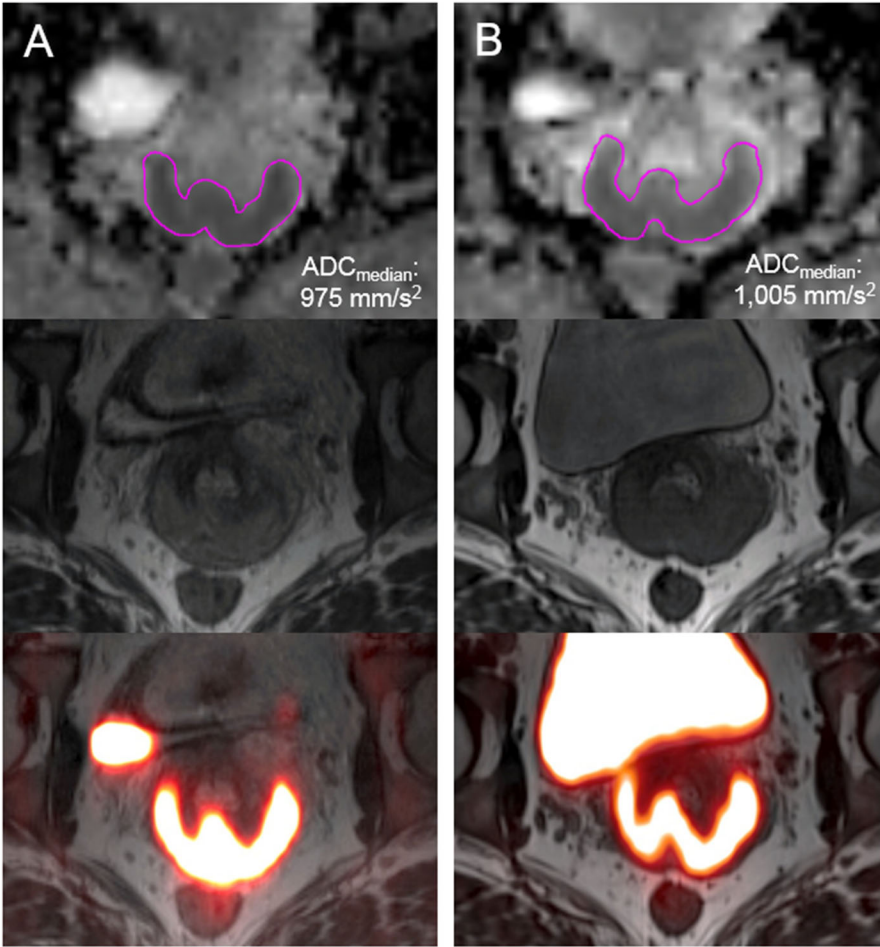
ADC_{median} repeatability from ADC map analysis. A 33-year-old woman with biopsy-proven squamous cell carcinoma of the cervix was imaged with 48 hours between session 1 (A) and session 2 (B). Transaxial ADC maps with manual contours (pink), T2-weighted MR images, and fused PET/MR images are shown from top to bottom for each imaging session. The ADC_{median} values for sessions 1 and 2 were similar.
